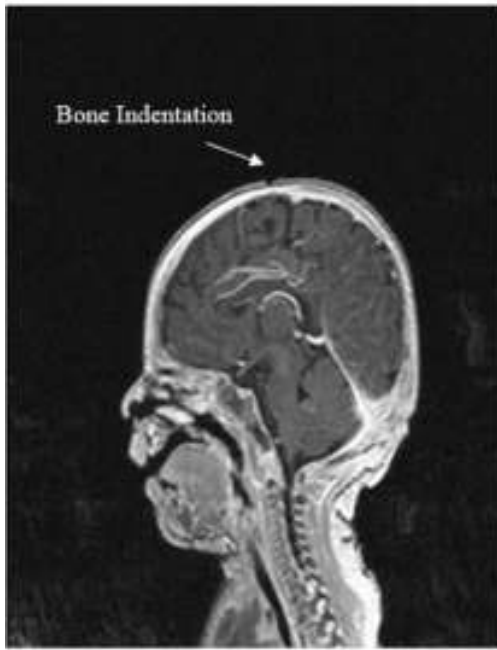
Bony indentation of skull in MRI
